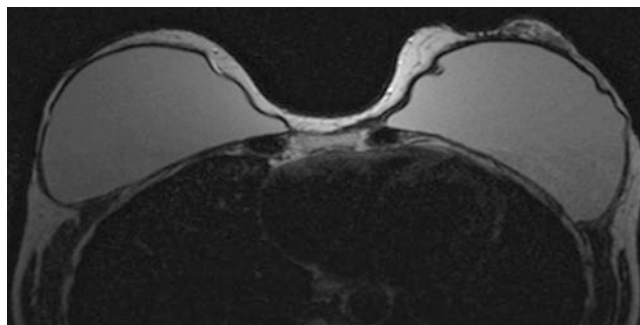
35-year-old patient with a history of right breast cancer and positive BRCA1. Right mastectomy and prophylactic left mastectomy were performed. The patient was not a candidate for mammography. Breast MRI was performed to check whether there was residual fibroglandular tissue. T2 sequence shows the presence of residual fibroglandular tissue with slight enhancement on the left breast. A follow-up MRI was recommended
